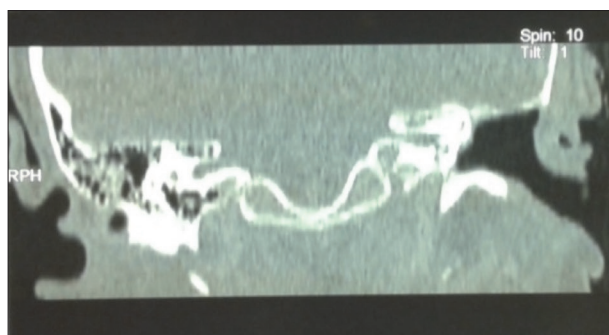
Coronal Computed Tomography scan after radical tympanomastoidectomy showed normal findings
